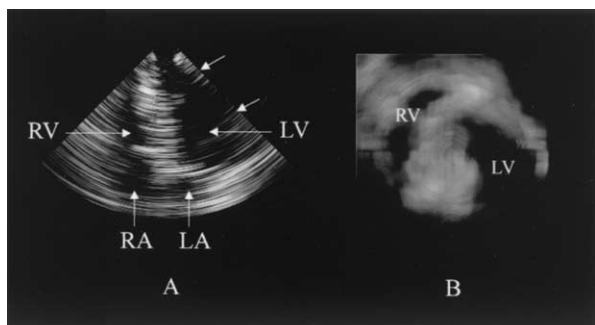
(A) 10-cm deep apical four-chamber B-scan made with the 22-F catheter in a surgical trocar positioned subcutaneously. Right ventricle (RV), left ventricle (LV), right atrium (RA) and left atrium (LA) are seen. (B) 3-D rendered view of the volume of data in between the arrows to the right of the B-scan showing the LV chamber and crescent-shaped RV.
